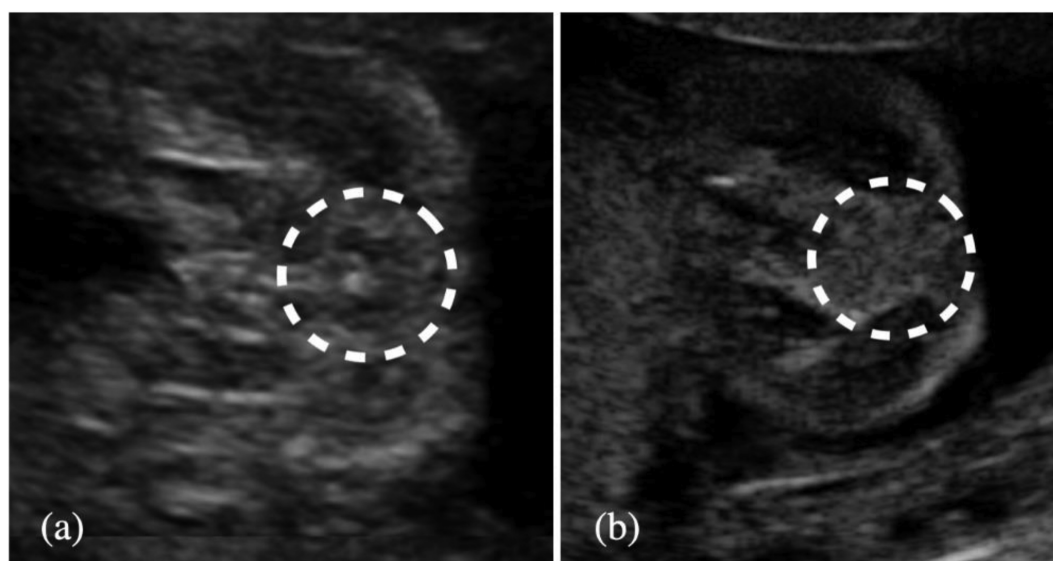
Appearance of direct findings of anorectal malformations in 2D ultrasound.
